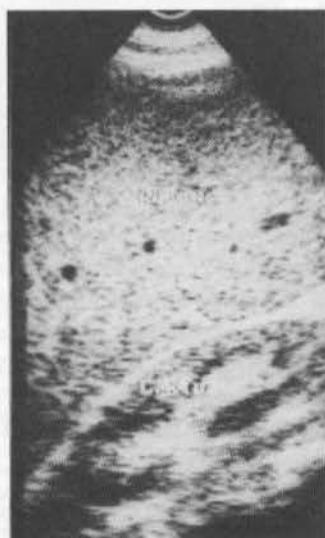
Sonogram of the spleen before treatment.
